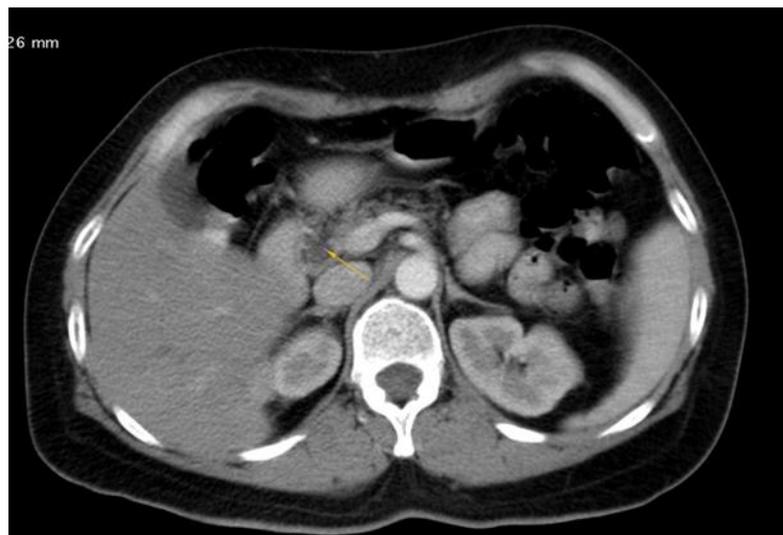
Axial contrast-enhanced CT image at a similar level showing homogeneous fat-density replacement of the entire gland (orange arrow indicating the extent of fatty change in the pancreatic body/tail). Note the absence of ductal dilatation or enhancing solid masses. The surrounding vessels and structures are clearly delineated.
